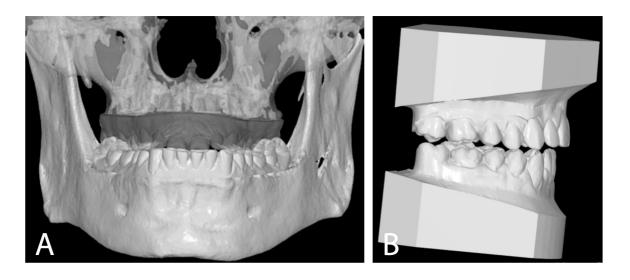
(A) A CBCT DICOM file with maxillary and mandibular STL digital scans orientated and aligned and in occlusion in a virtual articulator. (B) Maxillary and mandibular digital casts.
